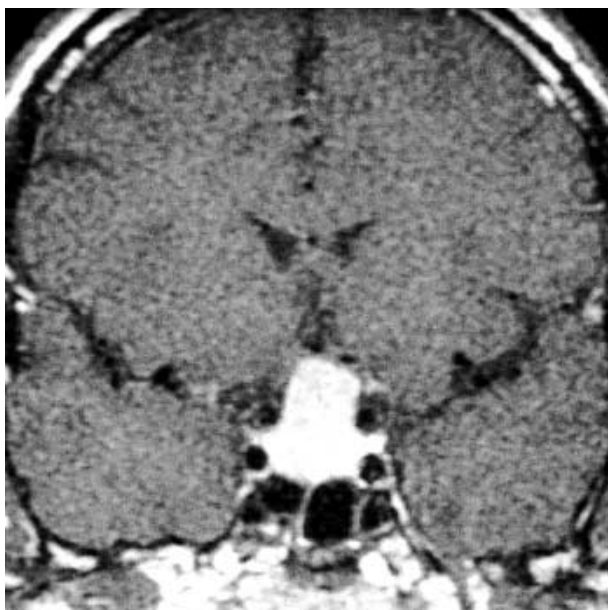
T1-weighted coronal magnetic resonance image shows a gadolinium-enhancing mass in the sella turcica.
